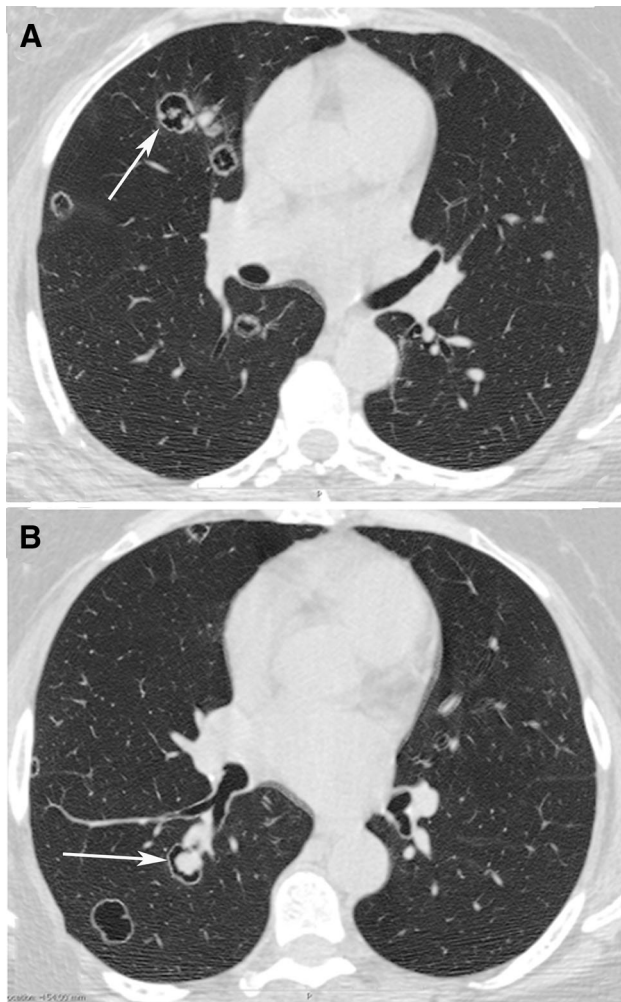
Metastases. A 37-year-old woman with uterine metastases. Axial CT images obtained with lung window settings (a, b) show several cavitated nodules, some with intracavitary nodules (arrows), in both lungs
